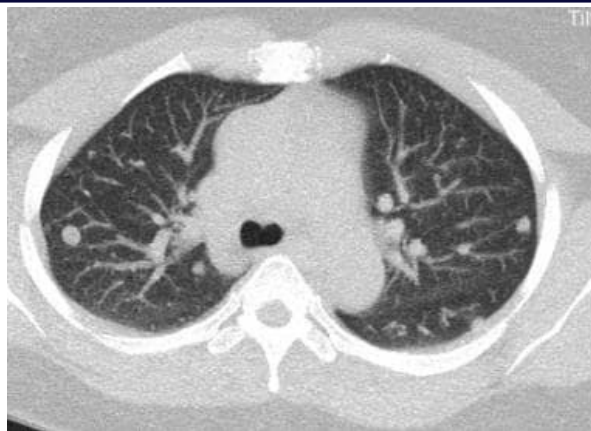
Axial CT scan of Thorax at the level of pulmonary artery bifurcation demonstrating multiple round nodules.
